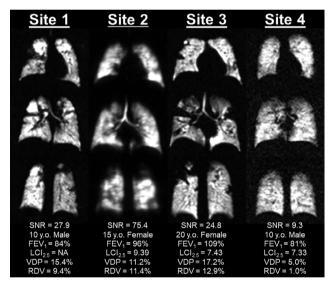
Inter-site comparison of Xe image quality. Four representative cases with demographics, FEV_1 , and $LCl_{2.5}$ are shown, one from each site. These were all data from Visit 1, Scan 1 of the study. Xe MRI SNR, VDP, and consensus RDV measurements are given.
